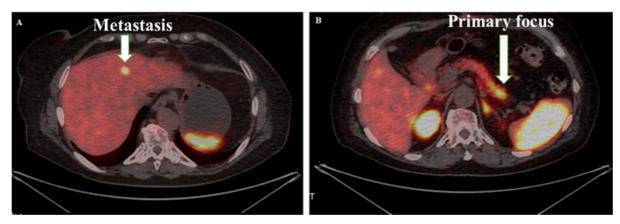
(A). Picture of the focus of pathological accumulation (metastasis) of 68Ga-DOTA-TATE in S4 liver with dimensions of 14mm with SUV=8.5. (B). Focal hyper fixation (primary focus) of 68Ga-DOTA-TATE in the distal parts of the tail of the pancreas with dimensions of 28*17mm with SUV=6.9
